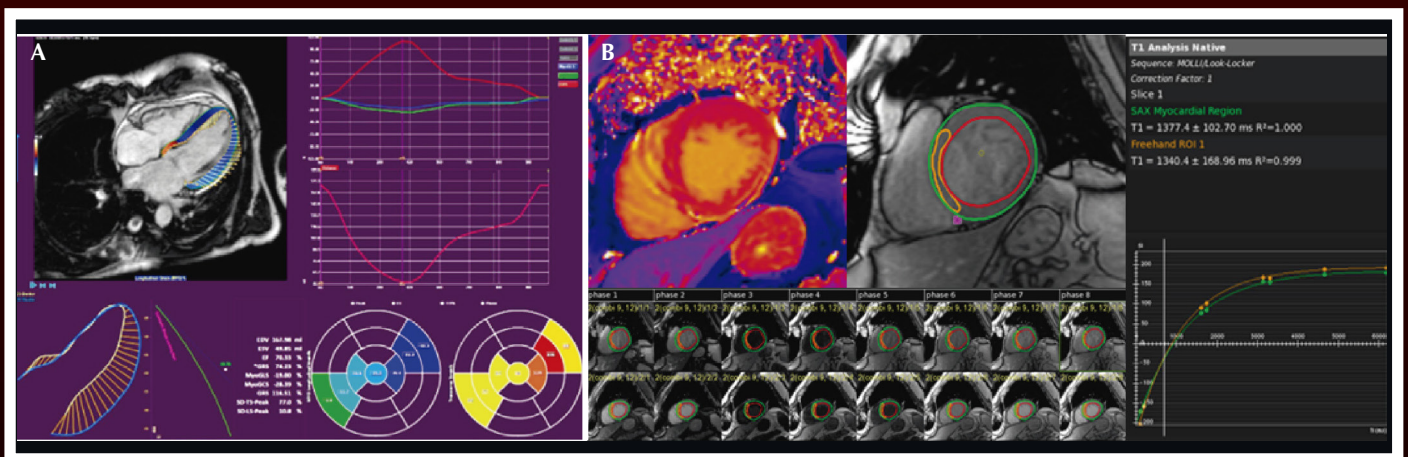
Advanced techniques in cardiac magnetic resonance imaging: (a) left ventricular myocardial strain by normal (global and segmental) strain; (b) abnormal left ventricular T1 mapping (high T1 values and increased extracellular volume in the septum of a patient with myocarditis).
